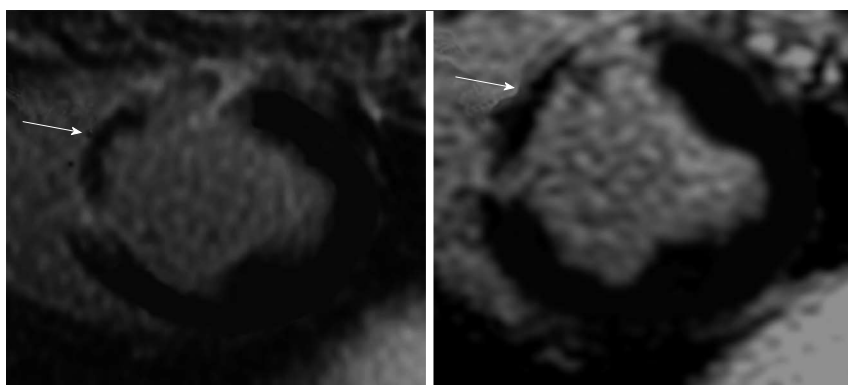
Delayed contrast enhanced magnetic resonance imaging of acute reperfused myocardial infarction (3 d) showing the hyperenhanced infarct and microvascular obstruction (arrows).
